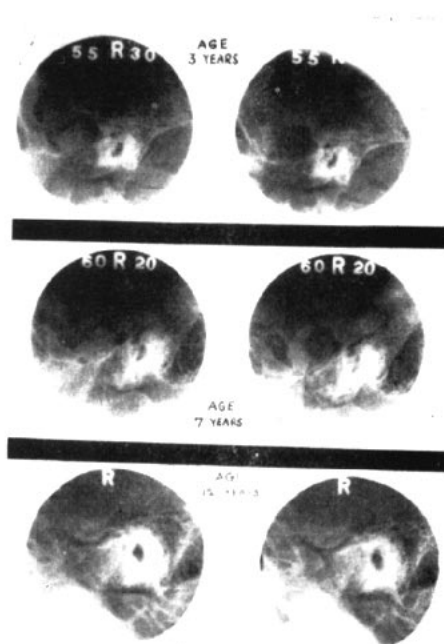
Radiographs of joints of children, age 3 to 12.
